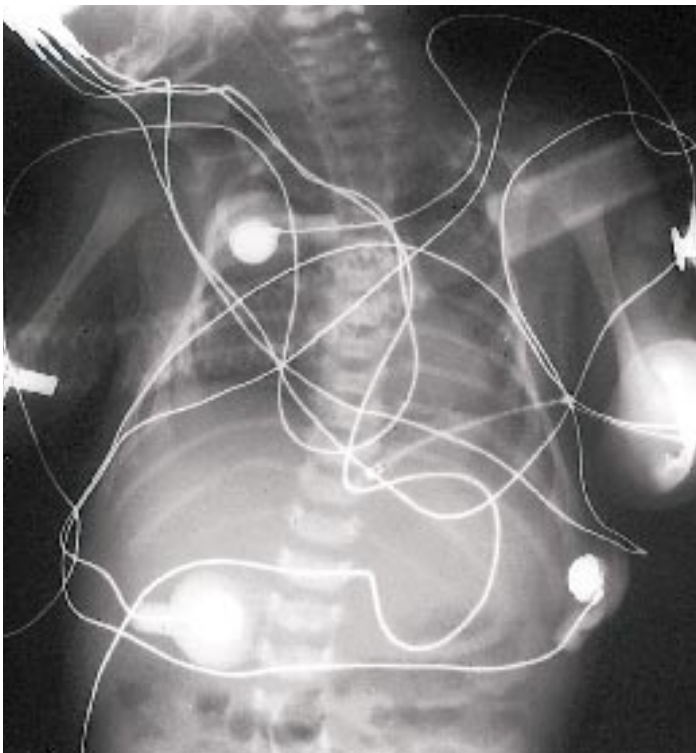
Radiograph of the chest of an infant admitted to the neonatal intensive care unit. Note the excessive neonatal equipment interfering with evaluation of the status of any cardiorespiratory pathology. When doing radiographic evaluation it is extremely important that an attempt be made to clear all the excess tubes and leads to obtain as clear a field as possible.
